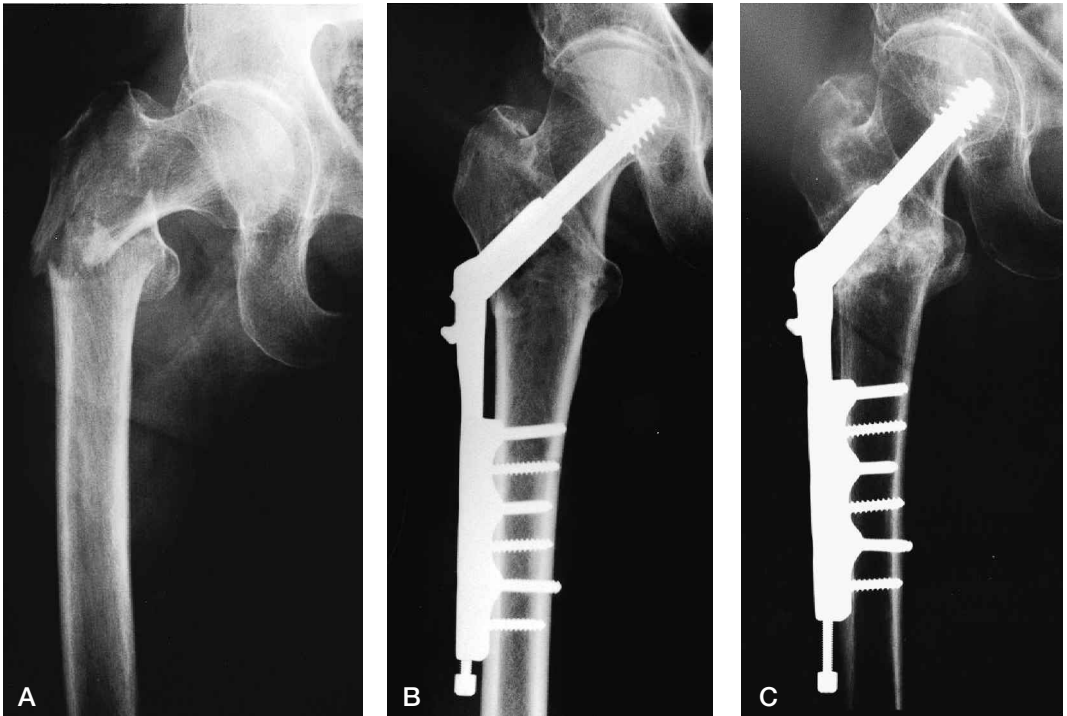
Preoperative (A) and postoperative (B) radiographs of a subtrochanteric fracture (Seinsheimer type 5) treated with a locked original 6-hole Medoff sliding plate. Axial shortening of 18 mm, but no medialization of the femoral shaft, varus angulation or migration, occurred and the fracture was healed at the 4-month control (C).
